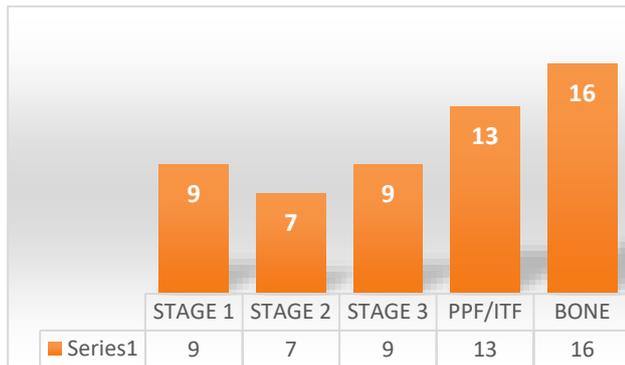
Extend of disease in second MRI.
